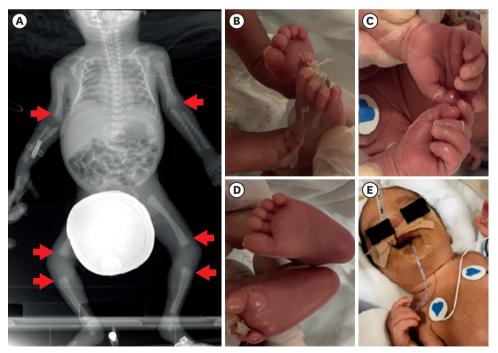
(A) X-ray of the patient on the 8th hospital day. Red arrows indicate osteolytic changes on the long bone ends. (B-D) Desquamation and peeling of the patient's hands and feet. (E) Jaundice in the face and body of the patient.
